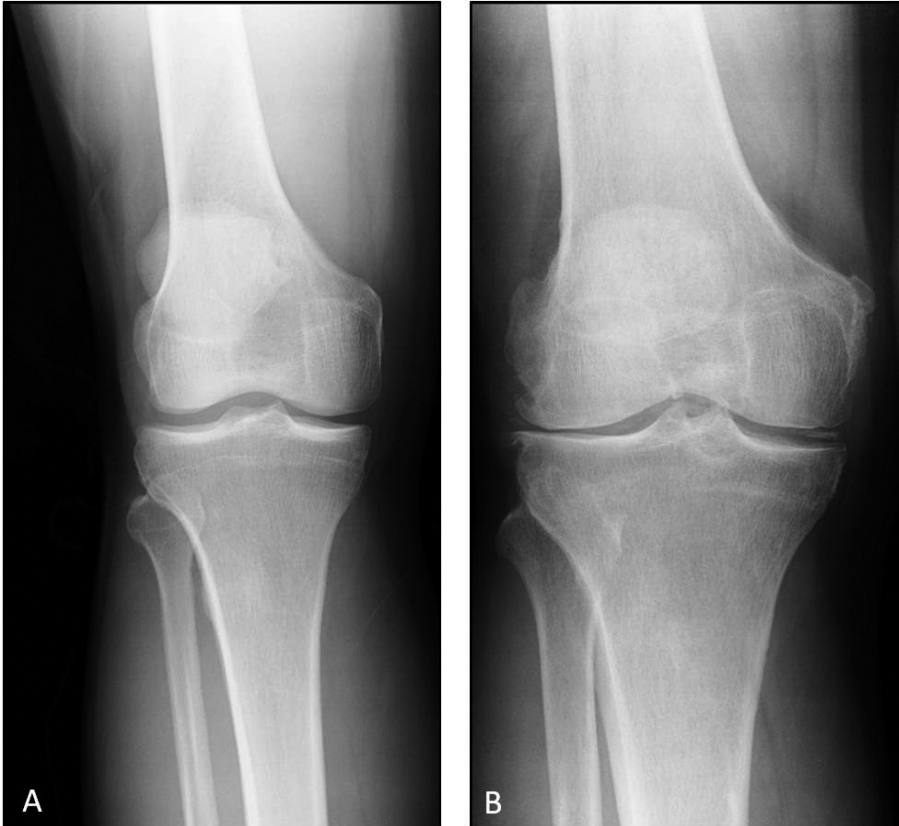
Xray anteroposterior projection in right normal and osteoarthritic knees from two different adult patients. A. Right normal knee. B. Right osteoarthritic knee, in the Xray there are radiographically visible changes such as narrowed joint space and thickening of the articular cartilage.
